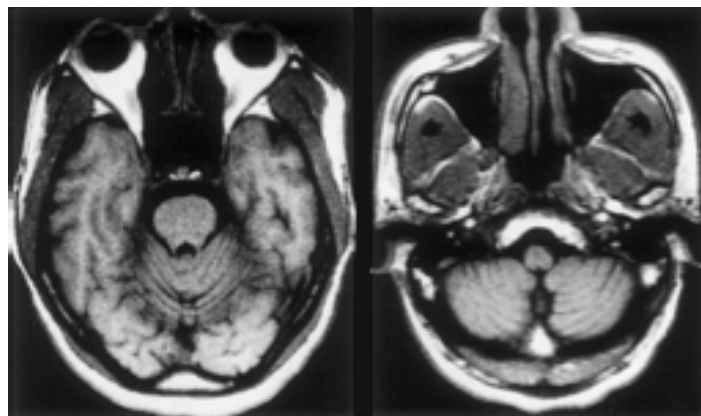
MRI studies of a MJD patient. The cerebellar signs (ataxia) presented by the patient correlate with the cerebellar atrophy shown (adapted from Buhman et al. 2003³⁰).
